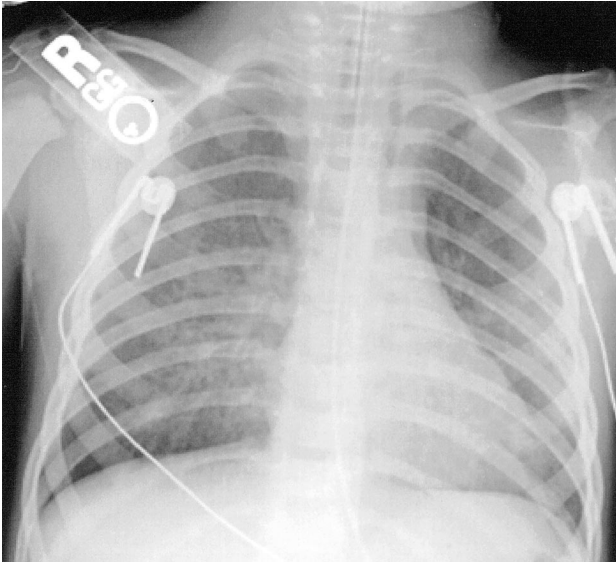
Radiograph after second endotracheal tube change.
